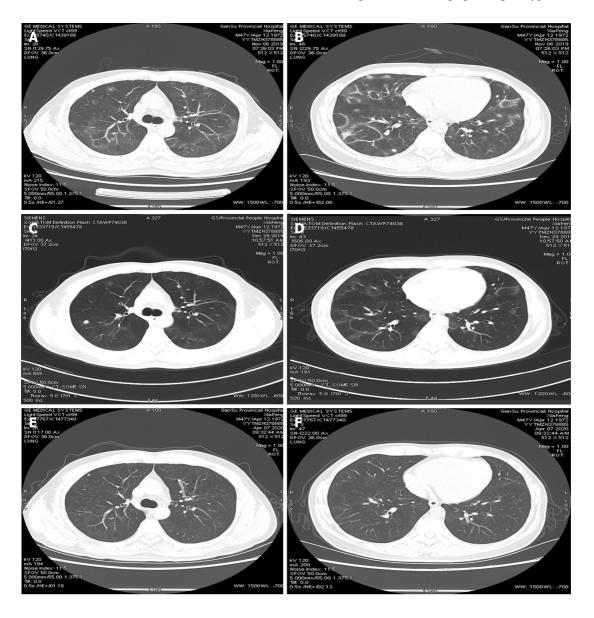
High-resolution computed tomography images. A: High-resolution computed tomography (HRCT) showed multiple nodules and ground-glass shadows in both lungs; B: Circular high density shadows of various sizes were widely distributed in both lungs with lung markings inside them; C: HRCT showed that the original nodules and ground-glass shadows were significantly absorbed at 1 mo, but a new nodule was found in the right upper lobe; D: Circular high density shadows were significantly absorbed at 1 mo; E: HRCT showed that the original nodules and ground-glass shadows were significantly absorbed; F: HRCT showed that the original circular high density shadows were significantly absorbed.
